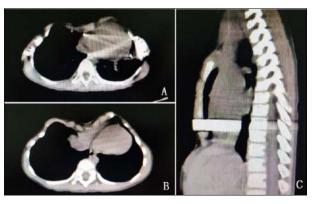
Preoperative CT examination. A, B. Sectional view; C. Sagittal view
